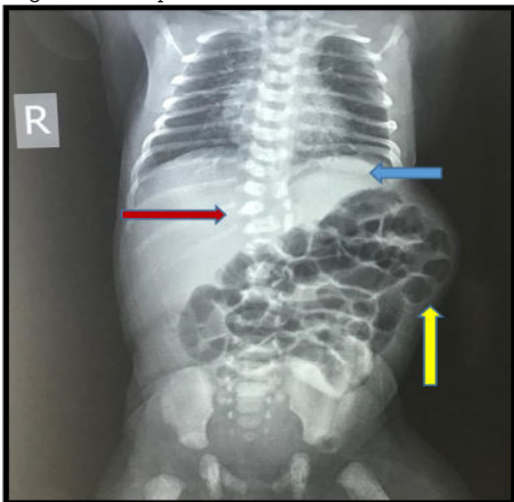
Roentgenogram showing dysplastic 9th, 10th, 11th, 12th
